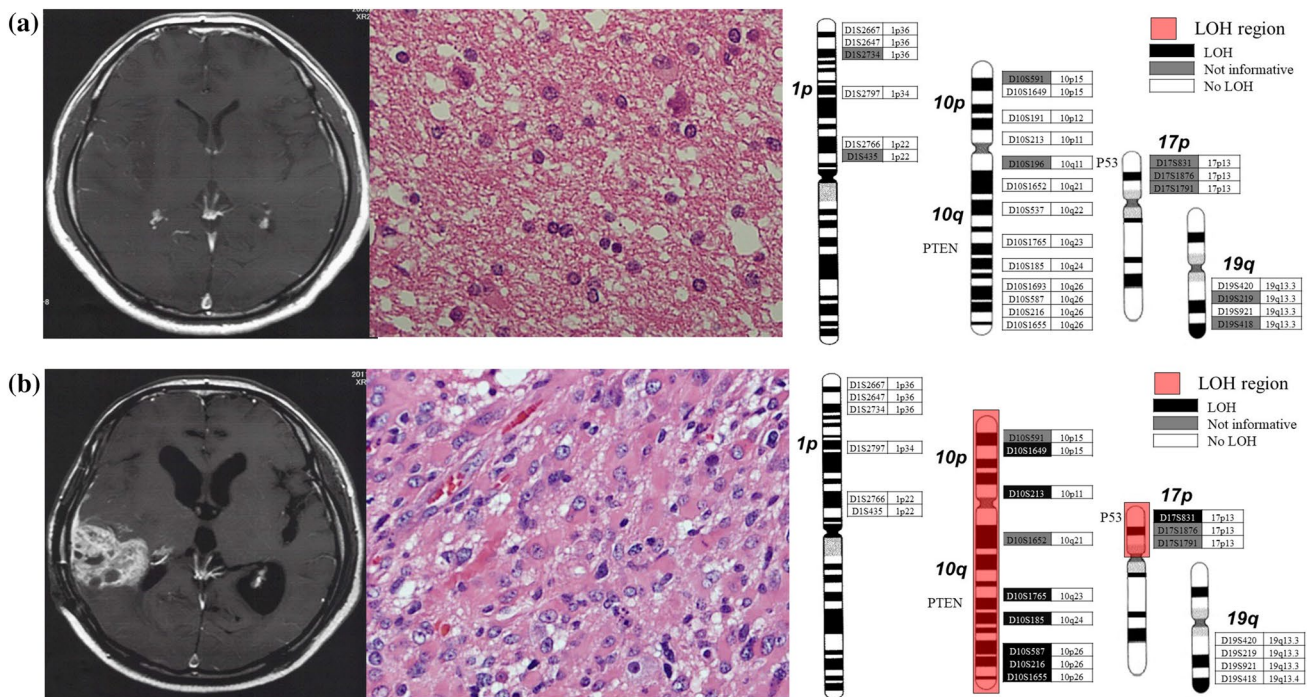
A 44-year-old male diagnosed as Molecular GBM: The patient underwent four surgeries. MRI showed a non-enhanced mass in the right temporal lobe. First diagnosis is a diffuse astrocytoma, grade 2 without any LOH region (a). After repeat surgeries and adjuvant
